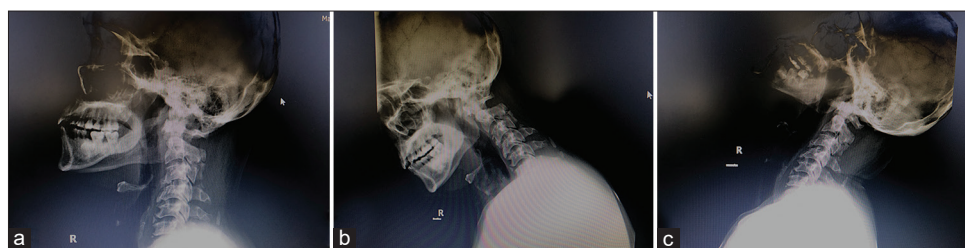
Cervical spine X-ray. (a) Lateral, (b) flexion, and (c) extension.
